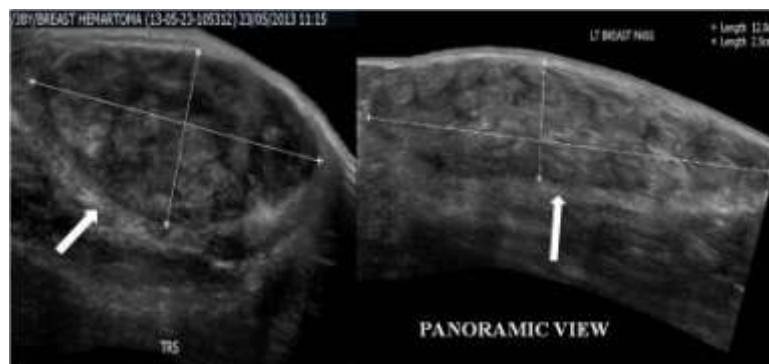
Ultrasonogram: A well defined, well-circumscribed, oval mass with heteroechoic internal pattern and peripheral echogenic halo
